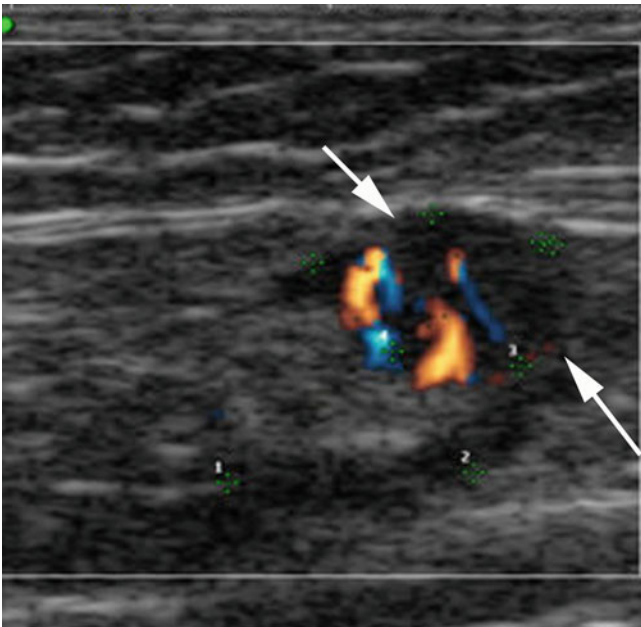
Metastatic lymph node, echo-free island. Directional power Doppler image. Lymph node of 12×8 mm (see set cursors) with an echo-free, hypervascularized island (6×5 mm, *arrows*)
